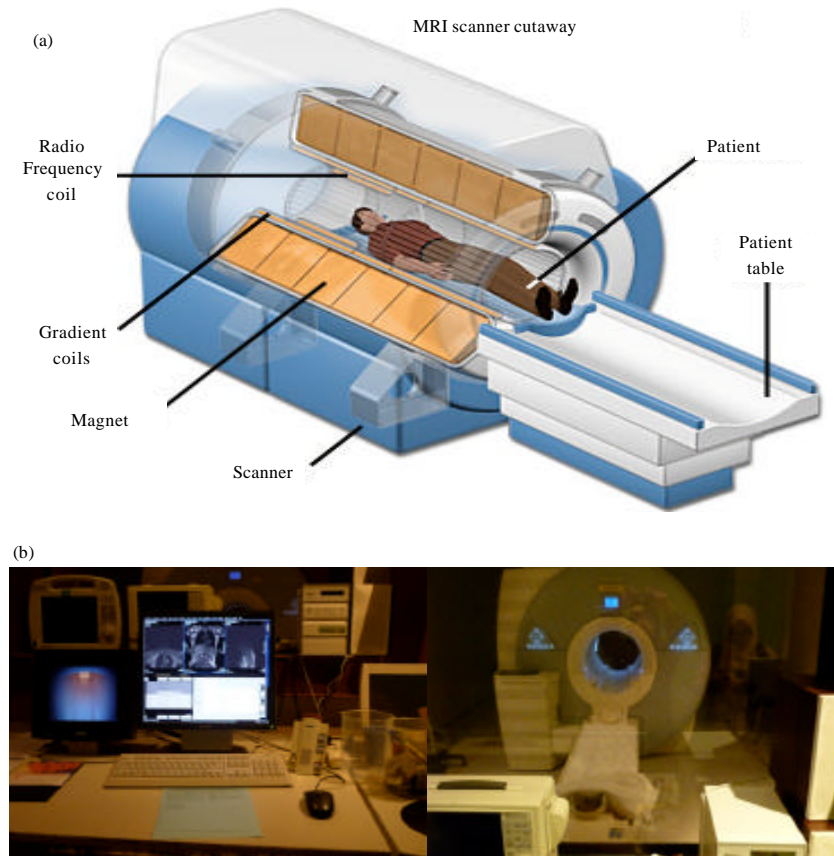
(a-b): (a) MRI scanner (Source: Coyne, 2012) and (b) UKM Medical Center, Malaysia
